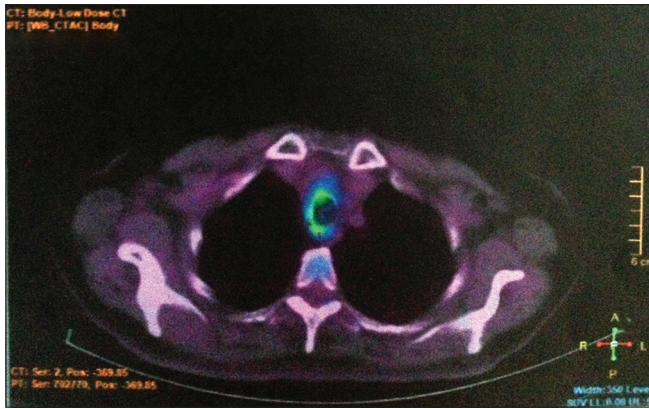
Staging positron emission tomography/computed tomography after endotracheal resection on April 2013
